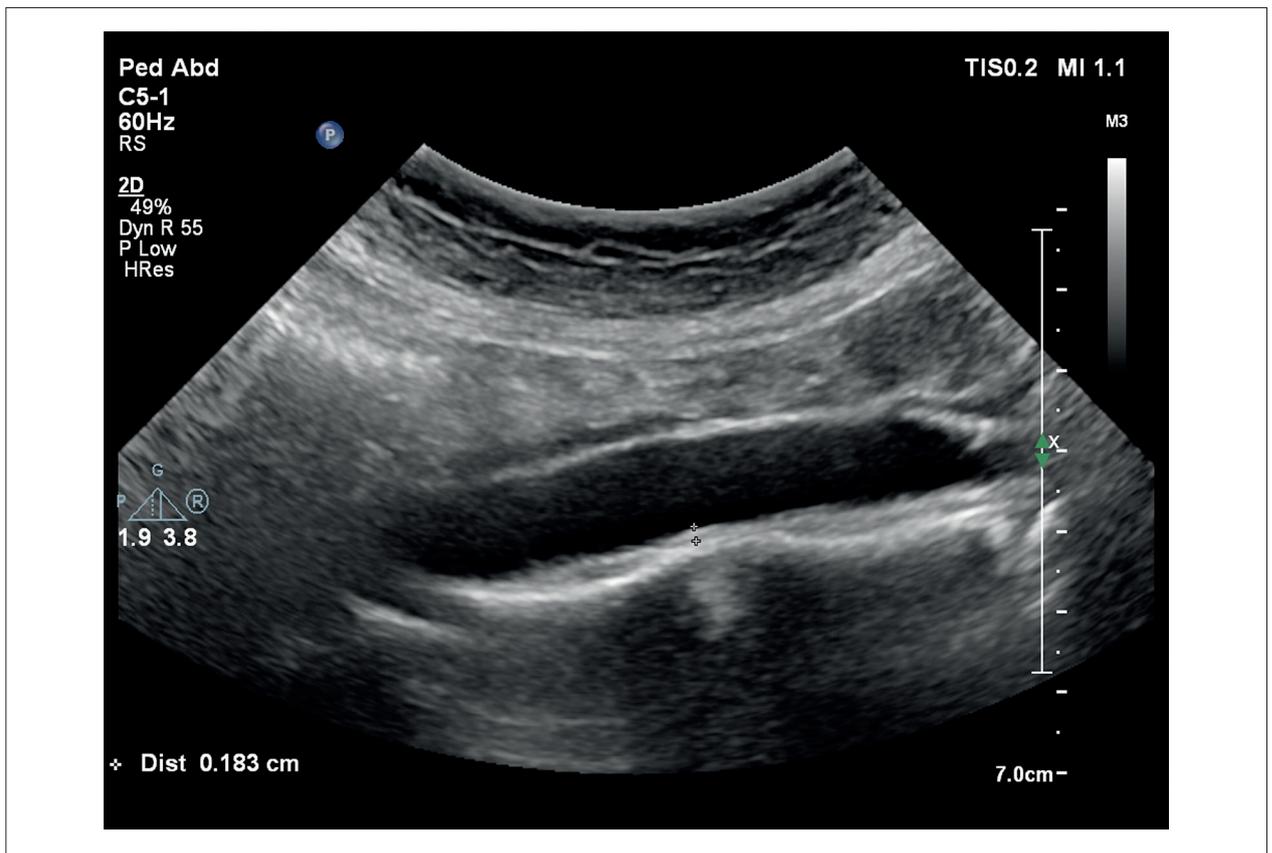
Abdominal aortic intima-media thickness (A-IMT) measurement by B-mode ultrasound showing increased A-IMT (1.83 mm) in a patient with beta thalassemia minor.
